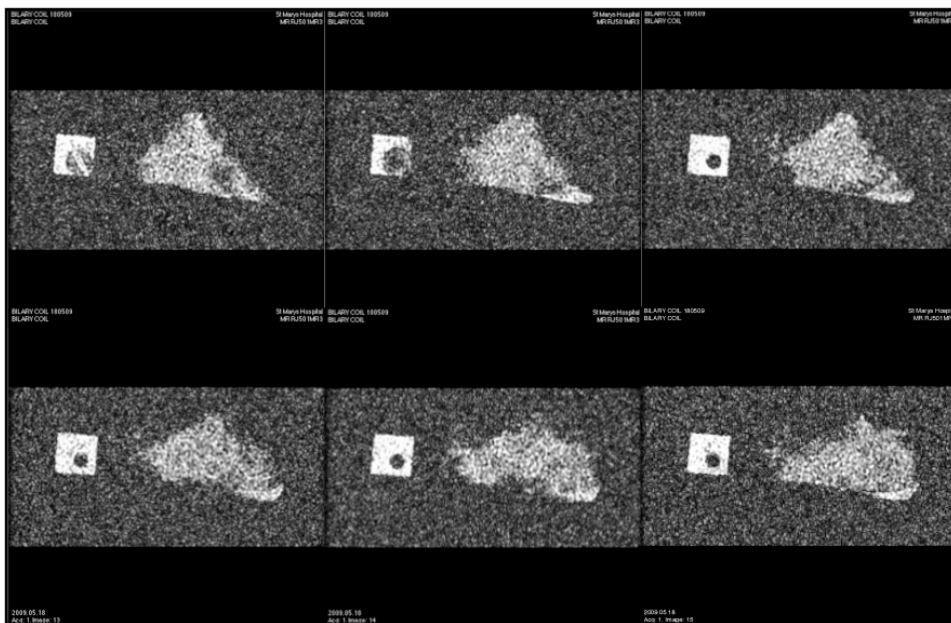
MR images of pancreas, obtained with microcoil
